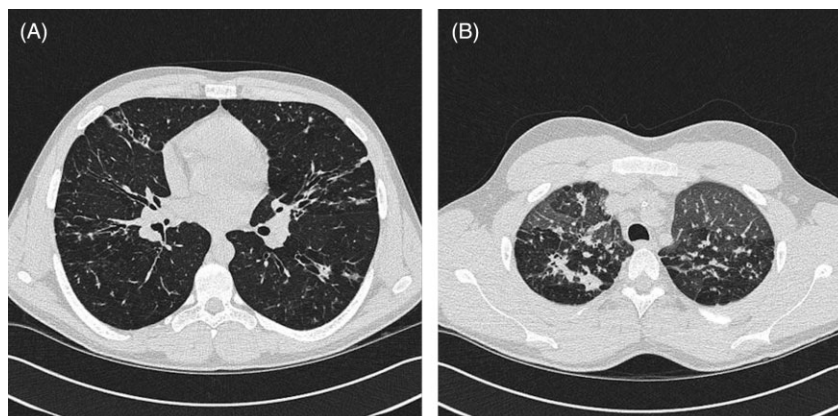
(A) Representative images from a computed tomography (CT) thorax of the cystic fibrosis patient, revealing significant bronchiectatic changes. (B) Expiratory images from CT thorax, revealing a mosaic pattern consistent with air trapping.
